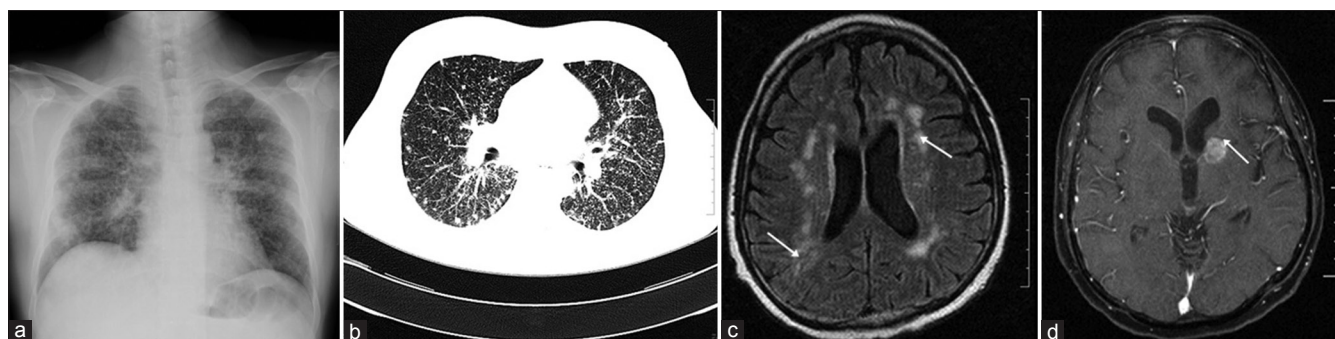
(a) X-ray chest (posterior-anterior view) showing bilateral miliary mottling. (b) HRCT of the chest showing bilateral miliary nodules with no lymph nodes or calcification. (c) MRI brain: T2 flare images show hyperintense lesions in the bilateral corona radiata region and in periventricular white matter (white arrows). (d) MRI brain showing cerebral infarct with a thin rim of hemorrhage anterolaterally (white arrow)
